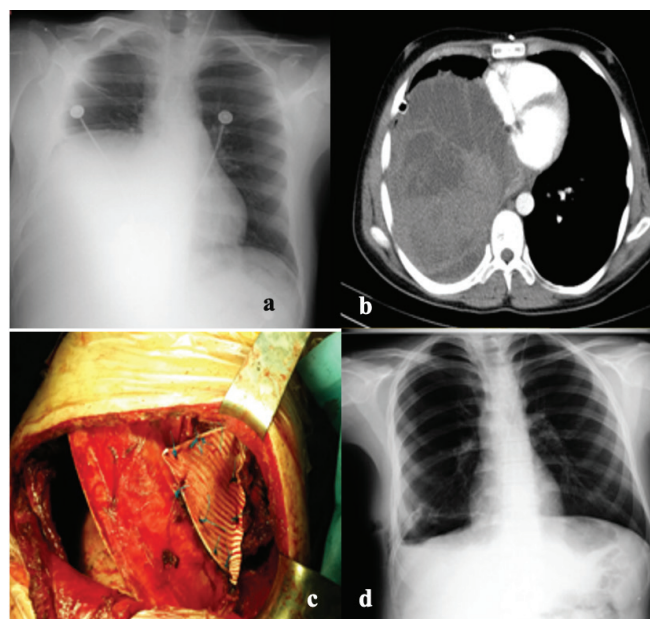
20-year-old male patient presented with a left lower lobe mass (Ewing Sarcoma). Preoperative chest x-ray and CT showing the mass, located in the right lower lobe (a,b), due to the invasion of the chest wall, resection and reconstruction with PTFE mesh were performed (c), postoperative chest x-ray of the patient (d).
